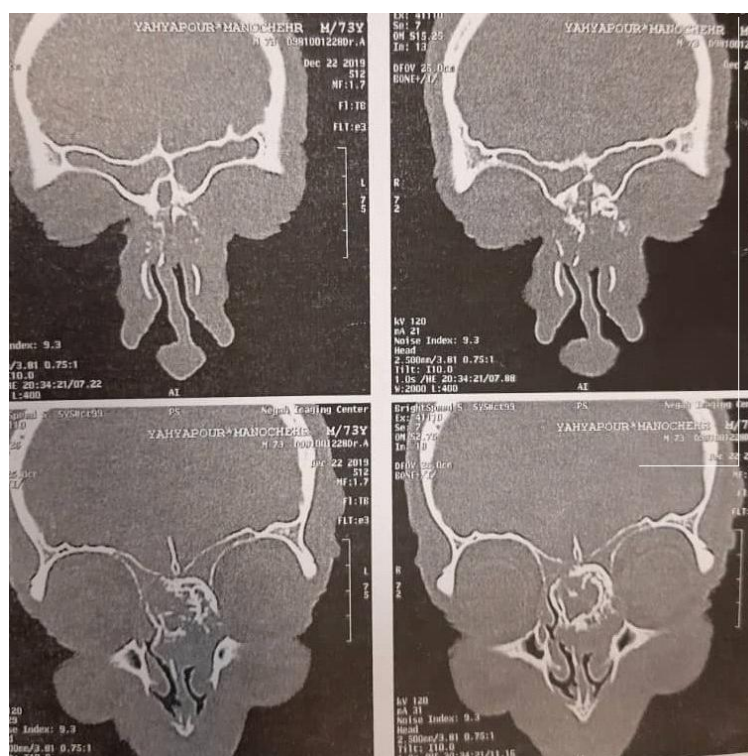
Chondrosarcoma CT-scan of ethmoid sinus with coronal cut
